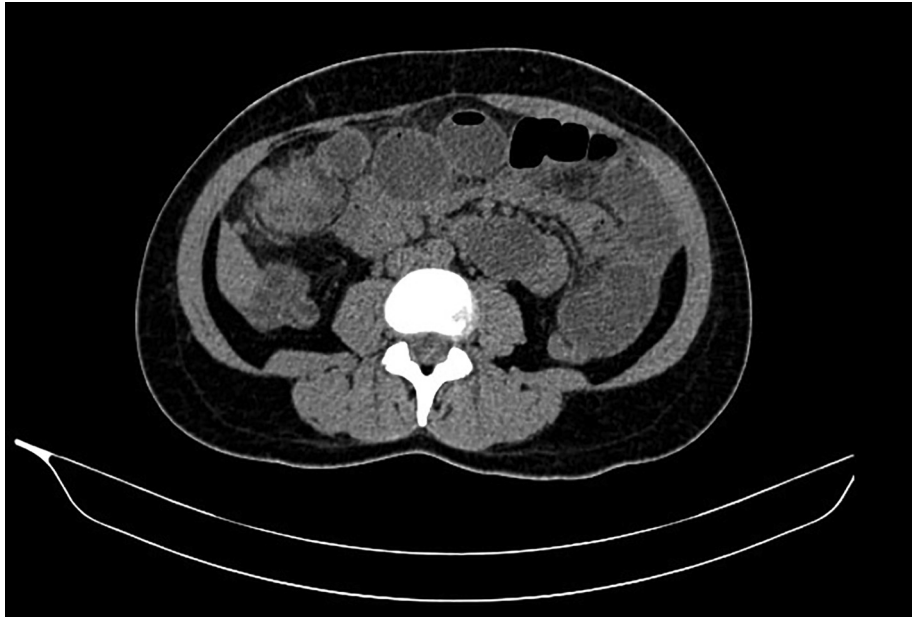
CT, showing dilated bowel loops.
